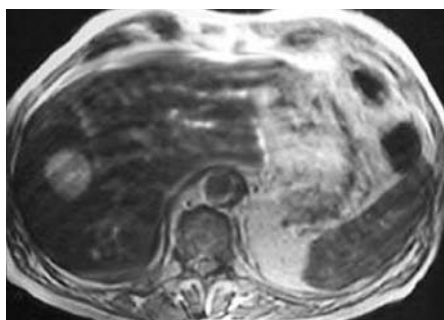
Moderate respiratory motion artifact degrades this T2-weighted SE image (TR 2500, TE 80) that required 12 minutes to acquire.
